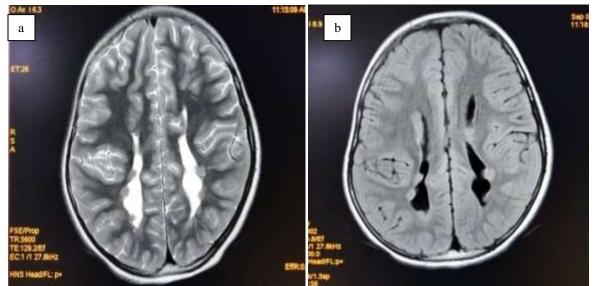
Axial sections of MRI. Sub-ependymal grey mater signal nodules are noted bilaterally on T2/FLAIR images, suggestive of sub-ependymal heterotopias.
